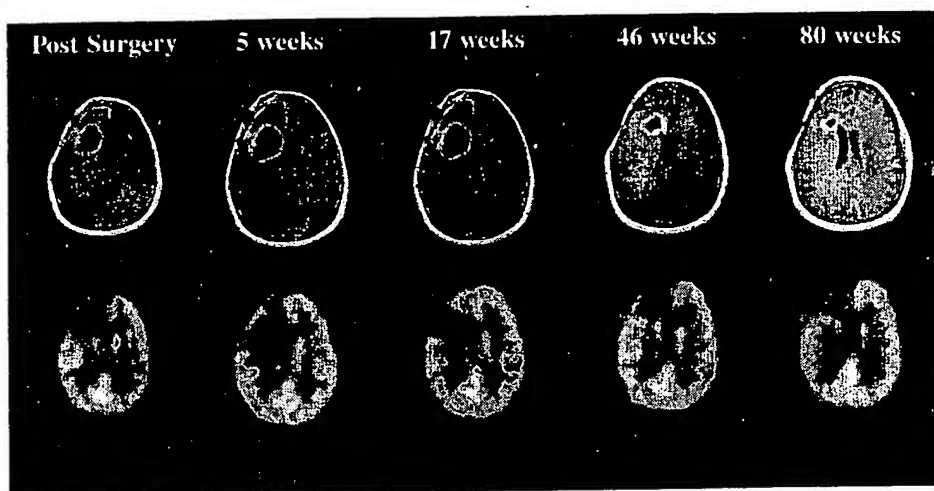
Serial MRI and  $^{18}\text{F}$ FDG PET scan results of a representative patient after  $^{131}\text{I}$  81C6 therapy. Over time, the SCRC gradually collapses as the rim develops more prominent enhancement. Corresponding  $^{18}\text{F}$ FDG PET scan images depicted below demonstrate a lack of increased metabolic activity in the region of the SCRC.
